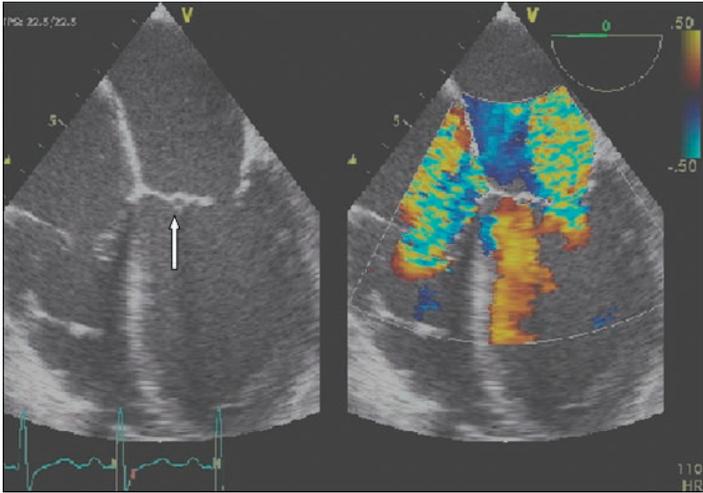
Transesophageal echocardiogram shows significant mitral and tricuspid regurgitation. Arrow points to thickened anterior mitral leaflet.
